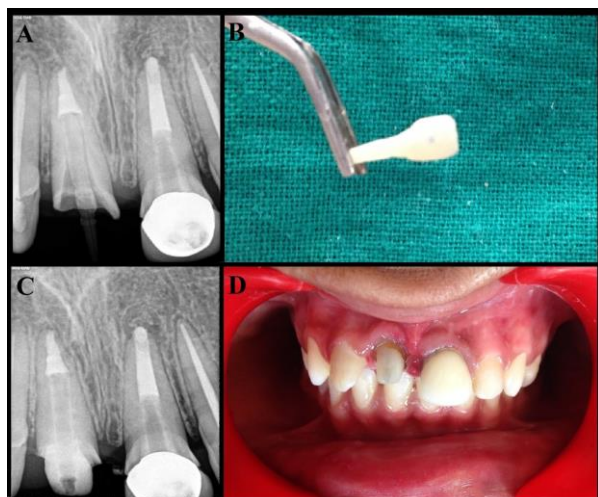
Radiograph showing inadequate adaptation of pre-fabricated fiber post to the post space. B. Aesthetic anatomic post and core assembly after custom fitting and extraoral curing. C. Radiographic view showing fit of anatomic post and core. D. Clinical photograph after post cementation.
